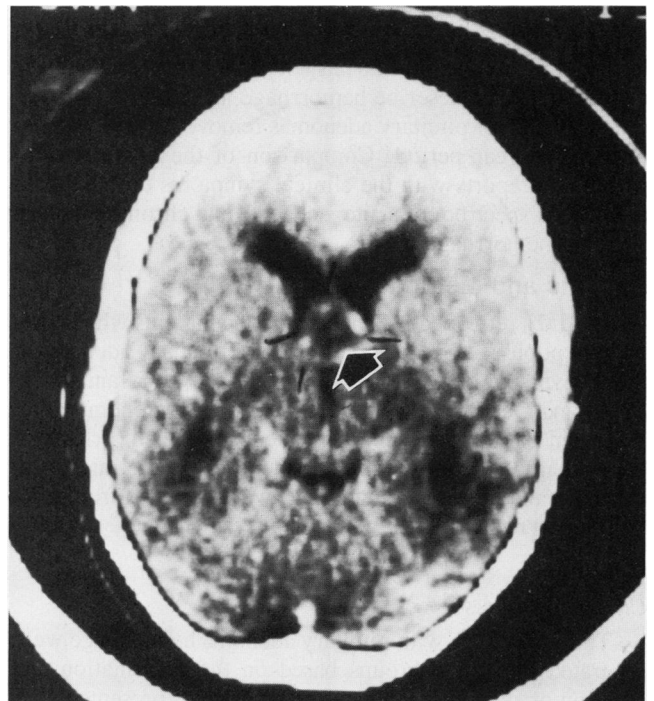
A computed tomographic scan of the head done several days after the onset of symptoms of pituitary adenoma hemorrhage. A contrast-enhancing rim around a central, low-density, hemorrhagic-necrotic area is seen (arrow).
